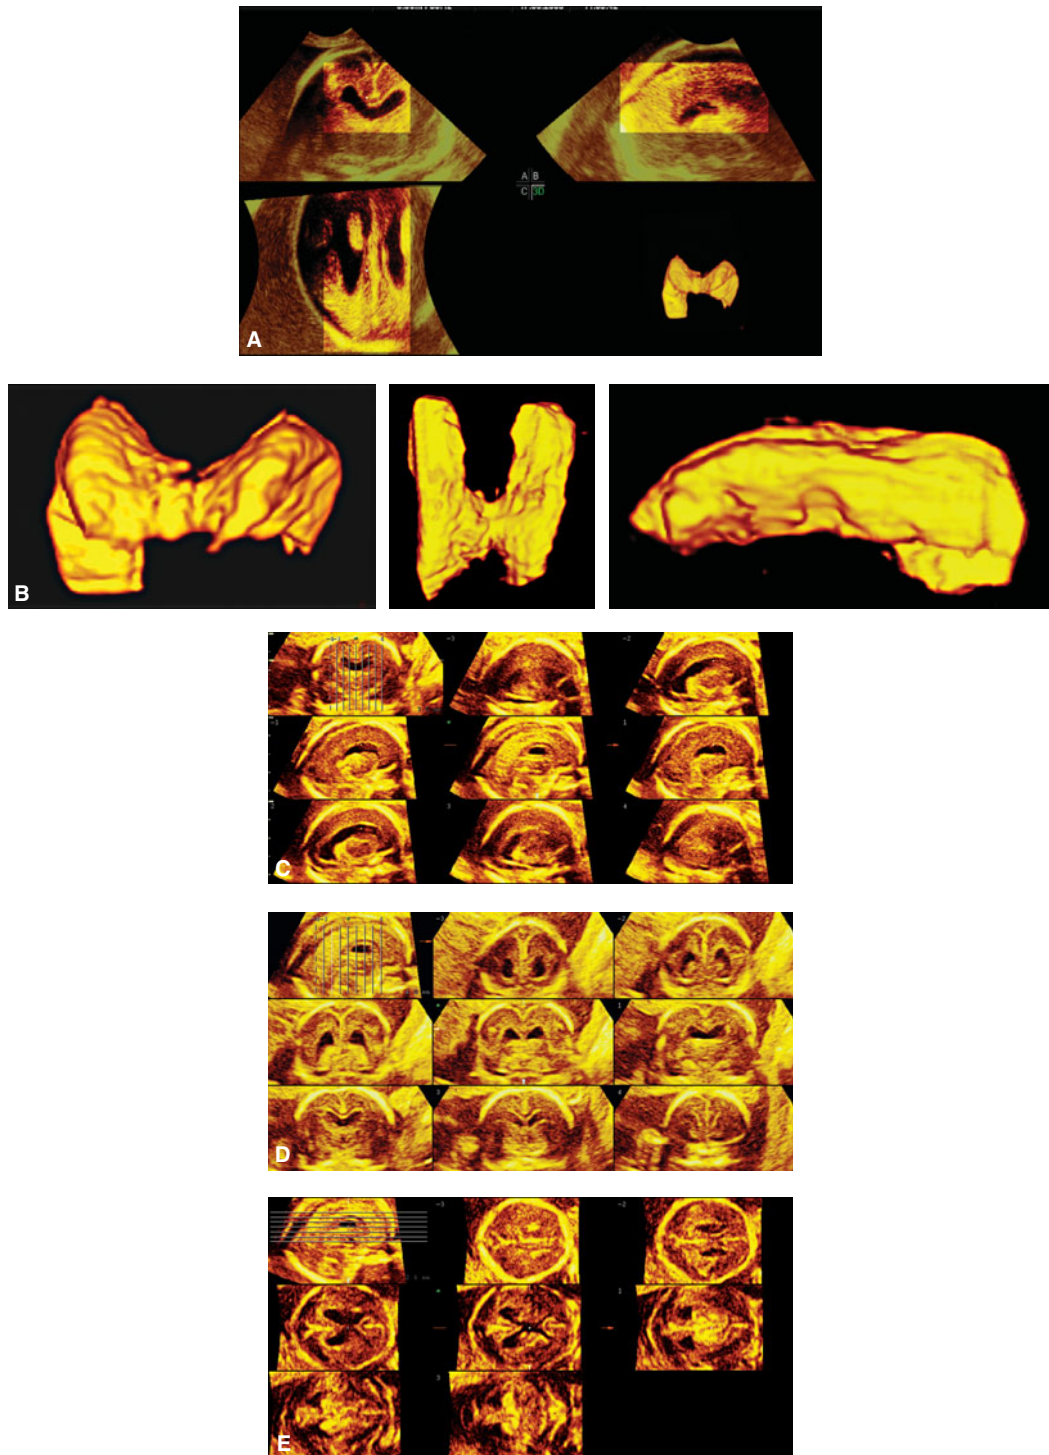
Sonography of fetal agenesis of the septum pellucidum: multiplanar imaging with three-dimensional rendering of the cavity of lateral ventricles (A); cast of the lateral ventricles obtained with three-dimensional ultrasound and inversion mode (B), tomographic images in the sagittal (C), coronal (D), and axial planes (E). (Courtesy Ilan Timor-Tritsch and Ana Monteagudo).
